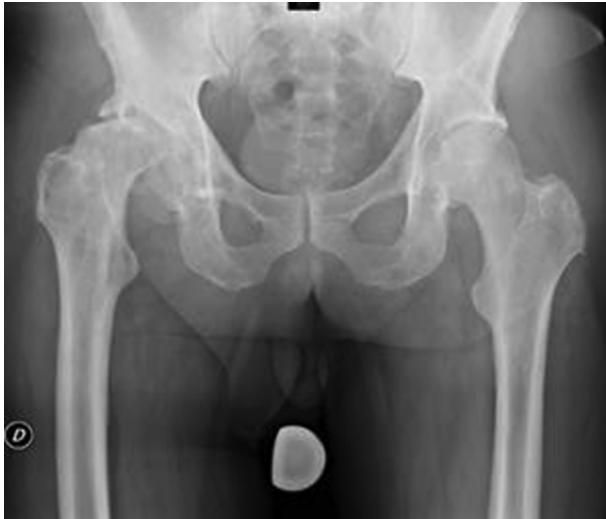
Pelvic preoperative X-ray film shows evidence of postradiation arthritis. Note the sclerotic bone in the superior acetabular zone.
